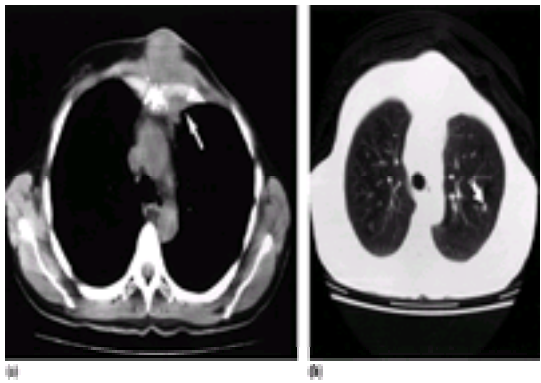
(a) CT section at the level of the arch of the aorta, displayed at window levels and widths appropriate to soft tissue. The section shows a large soft tissue mass arising in the anterior chest wall, with erosion of the sternum and extension into the mediastinum (arrow). This was due to recurrent carcinoma of the breast. Such images are useful to plan treatment fields for radiotherapy. (b) The same section displayed on lower window levels, showing the structure of the lungs. A small pulmonary metastasis is seen in the left lung (arrow), and was not detected on chest radiographs.
